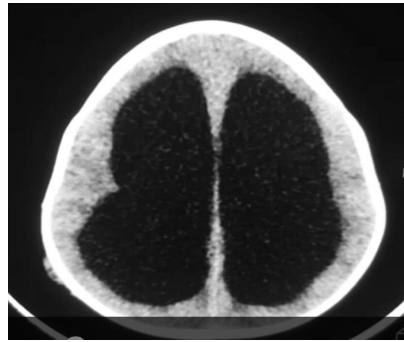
CT brain scan preoperative showing supra-tentorial hydrocephalus.
